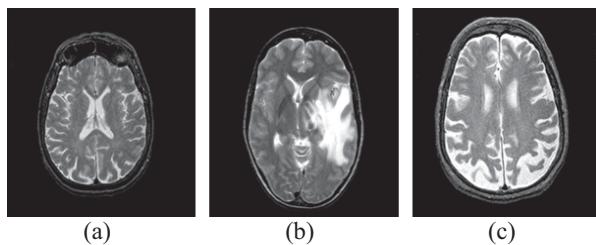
(a) A sample MR image of normal brain, (b) A sample MR image of abnormal brain, (c) Alzheimer's disease
